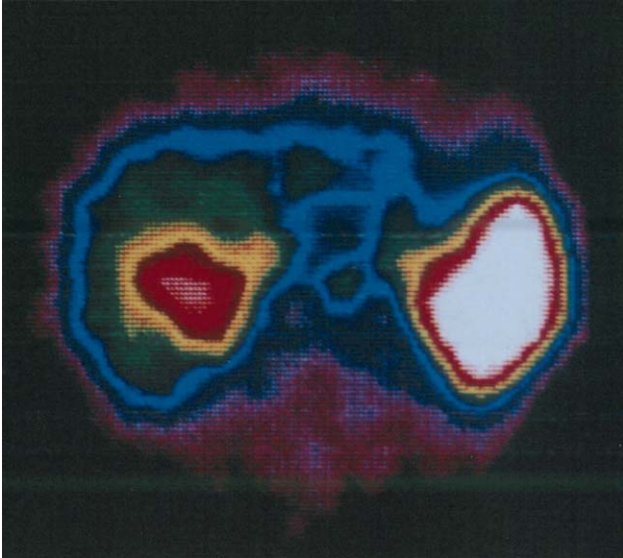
Red blood cell scintigraphy showing a radioactive pooling area (red) in the right lobe of the liver.
